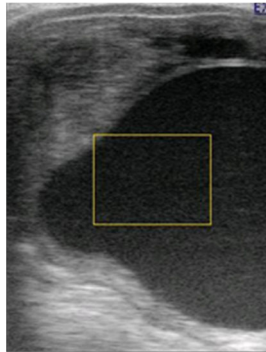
Ultrasonogram of left uterine horn of a mare; note the 55-mm cyst that completely blocked the lumen
